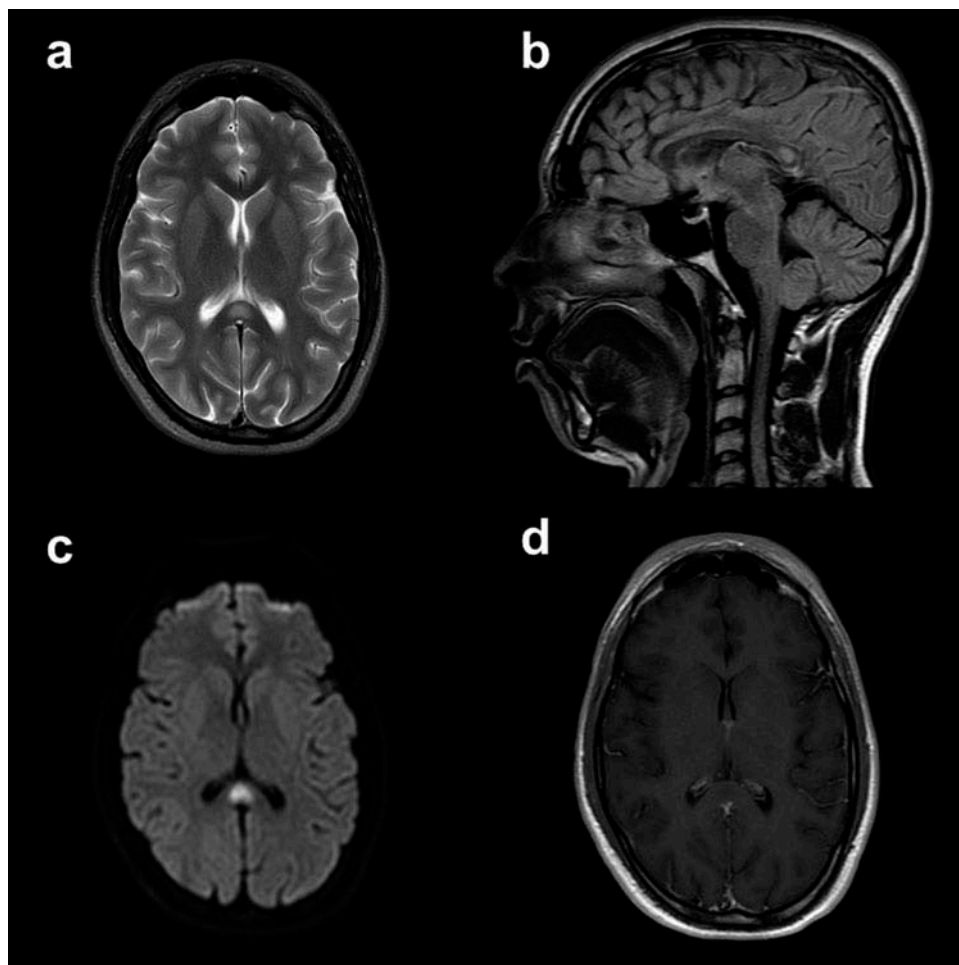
First MRI scan. (a, b) Axial T2 weighted and sagittal FLAIR images showed a well-defined hyperintense lesion in central SCC. (c) Diffusion-weighted image showed hyperintense restricted diffusivity within the lesion. (d) Axial contrast-enhanced T1 weighted image did not show contrast enhancement.
